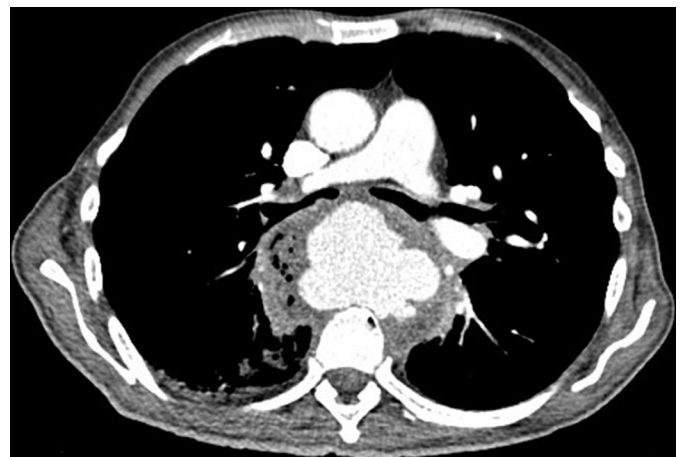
CT scan of the thorax showing a ruptured and inflamed mid-descending thoracic aneurysm compressing the esophagus.
